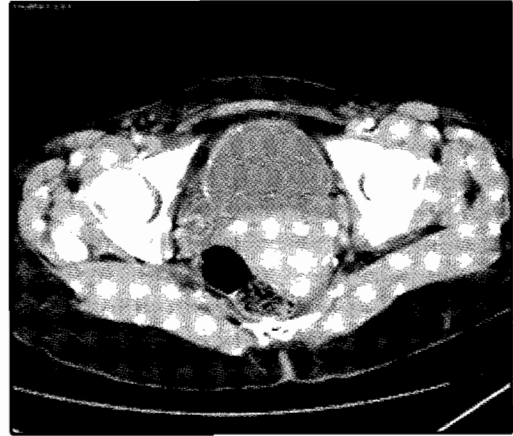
CT scan after treatment showing complete disappearance of the intramural gas in the bladder wall.
